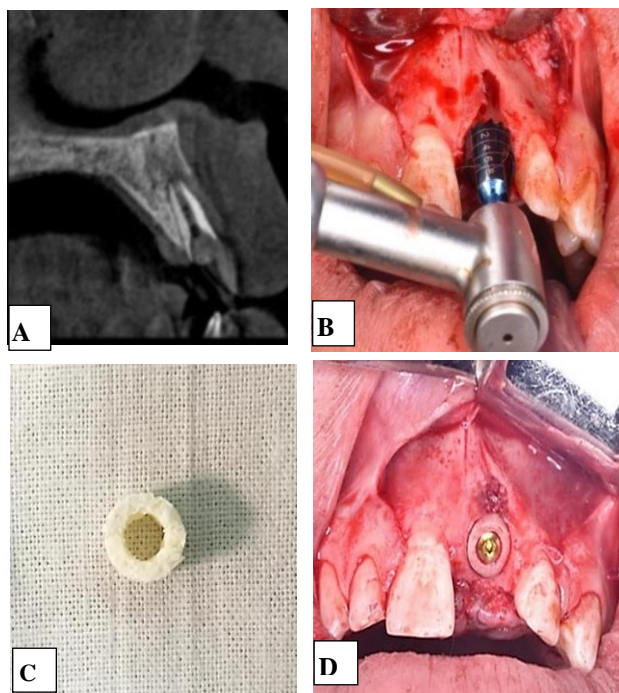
CBCT Preoperative Cross-sectional view (A). Preparation of recipient site by trephine bur 7mm(B). Allogeneic bone ring. (C). Implant with allogenic bone ring placement (D)
